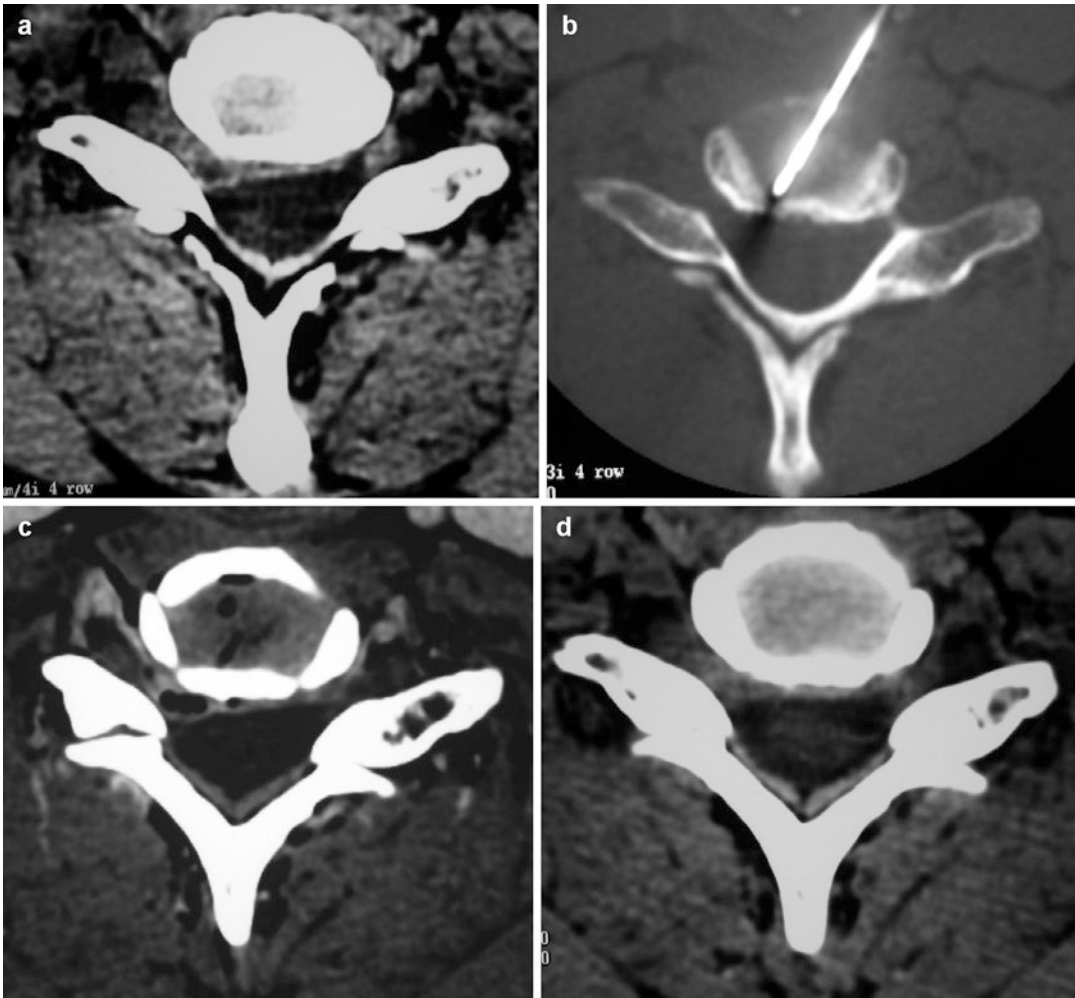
(a) Lateral disk herniation compressing the nerve root. (b) The cannula and SpineWand device are positioned under CT guidance and then safely and precisely directed toward the herniation. (c) Note gas from
